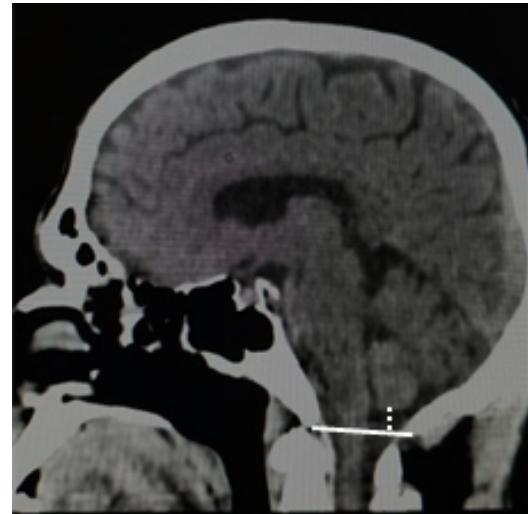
Sagittal reconstructed CT image of the brain demonstrating the procedure of obtaining the measurements to define the cerebellar tonsillar position. (Solid line: the line defining the position of the foramen magnum; dotted line: the measurement obtained from the foramen magnum to the lower border of the cerebellar tonsil).
